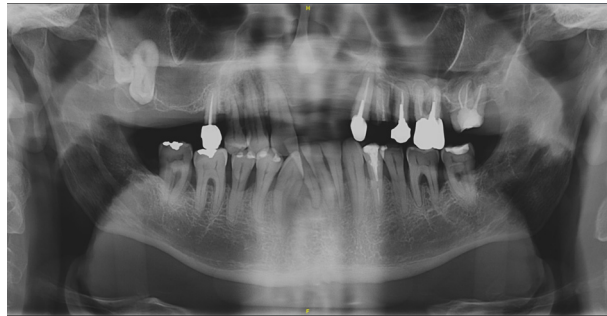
Panoramic radiography showing a large osteolytic lesion in the maxilla extending into the nasal cavity.
